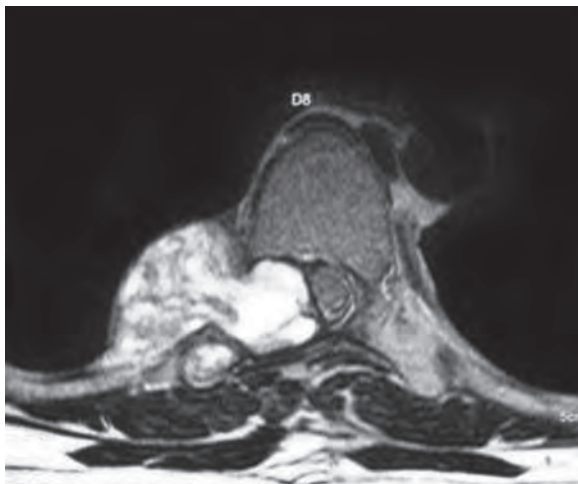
Post-contrast T1-weighted axial MR image shows a dumb-bell shaped dorsal (D8) schwannoma that extends into both the spinal canal and the thoracic cavity
